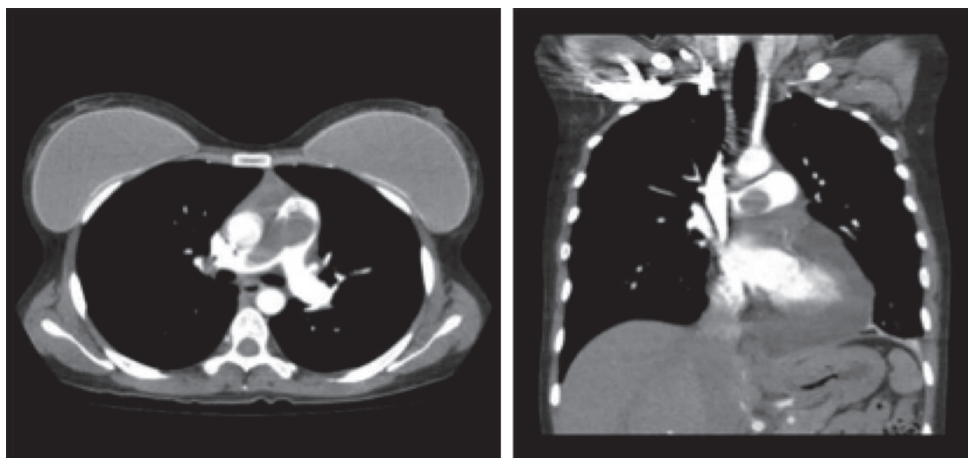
CT scan shows heart involvement, moderate pericardial effusion, and filling defect obstructing the main pulmonary artery and right branch
